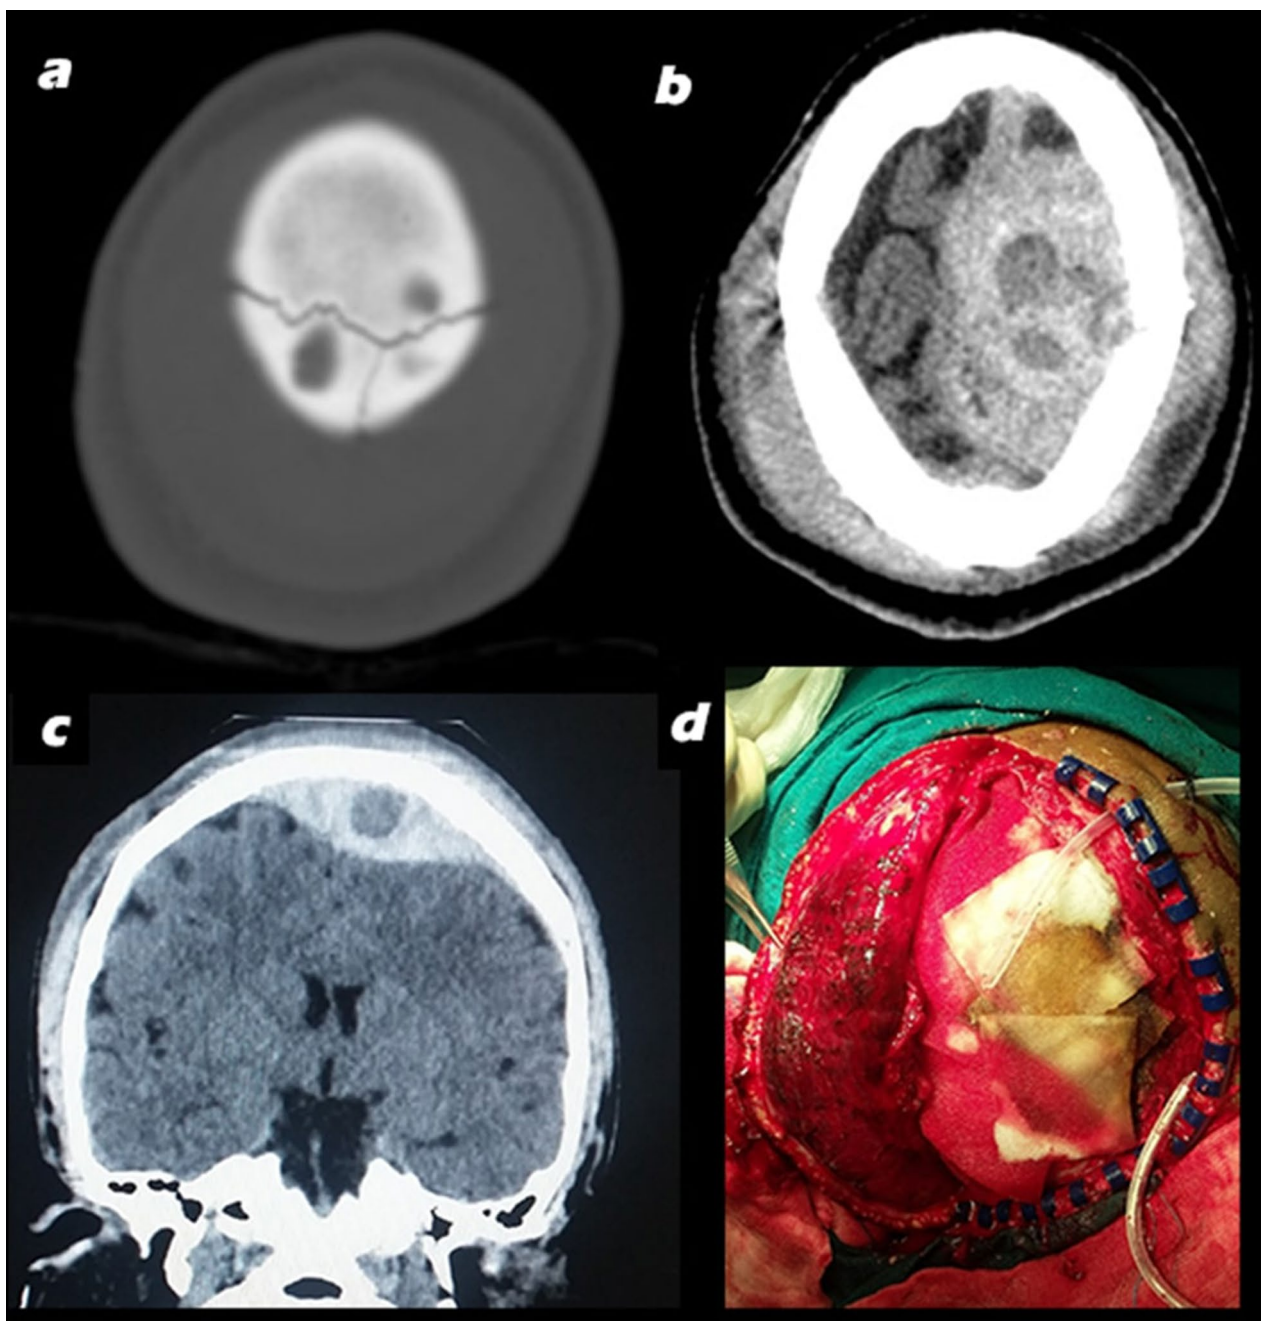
a Diastasis of coronal suture; b extradural hematoma from midline; c coronal reformat of CT showing hematoma crossing midline to right and swirl sign near midline suggestive of active bleeding; d bleeding controlled by Gelfoam soaked with thrombin–gelatin hemostatic matrix
